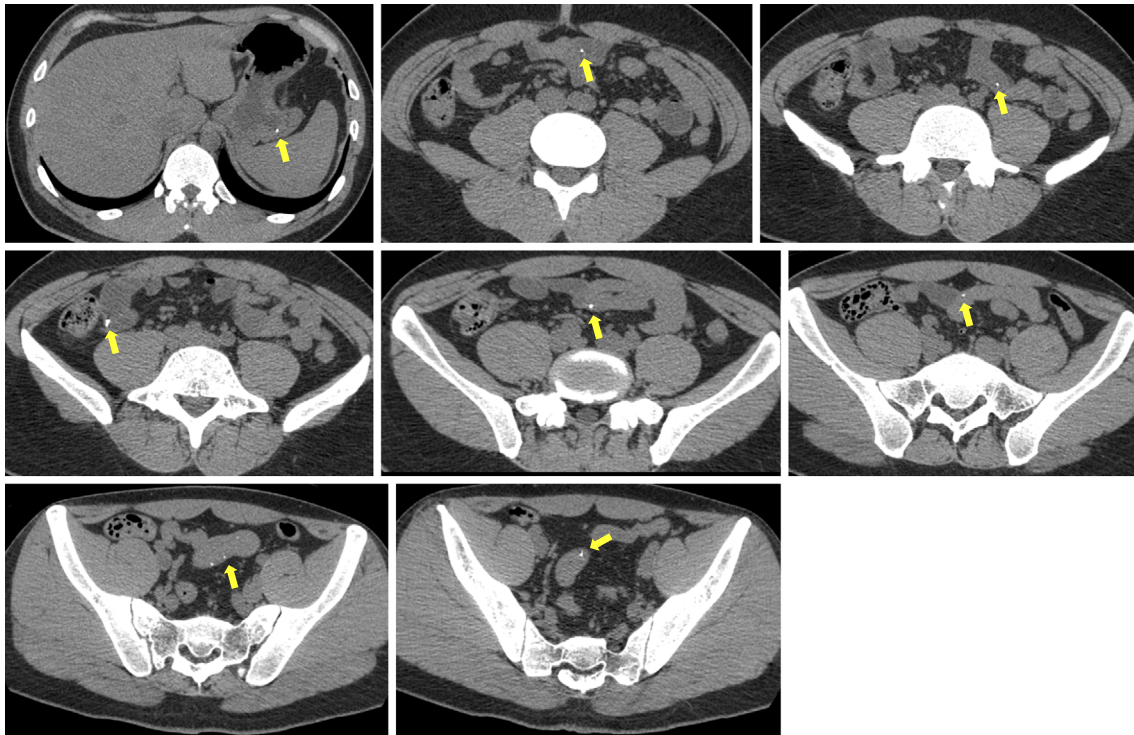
Non-contrast-enhanced abdominal computed tomography showing multiple small, high-density areas in the small bowel (yellow arrows).
